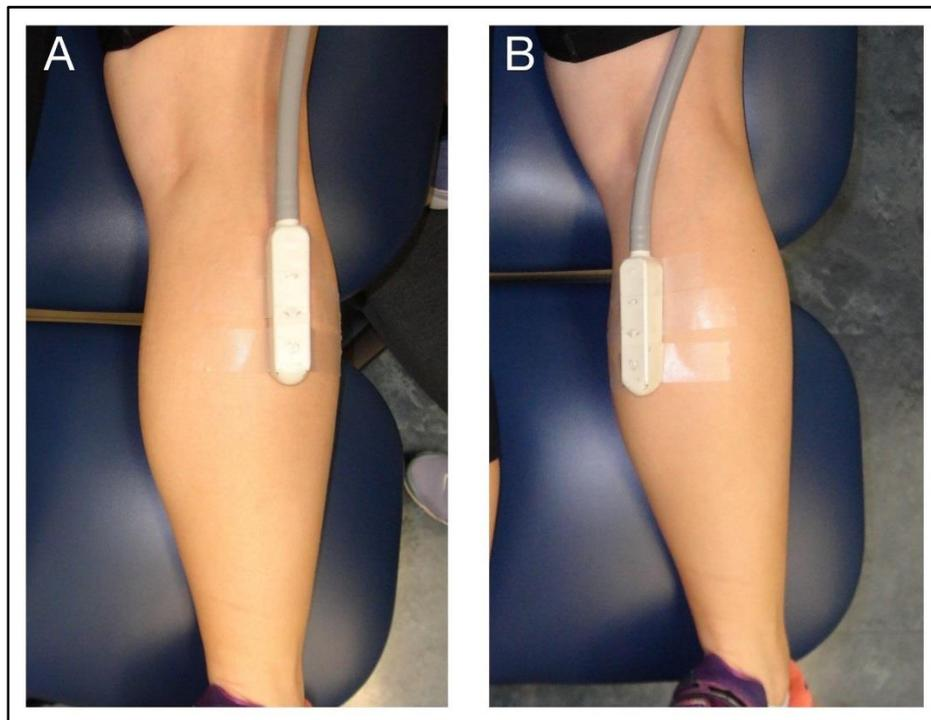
Placement of ultrasound probe over MG and LG.
